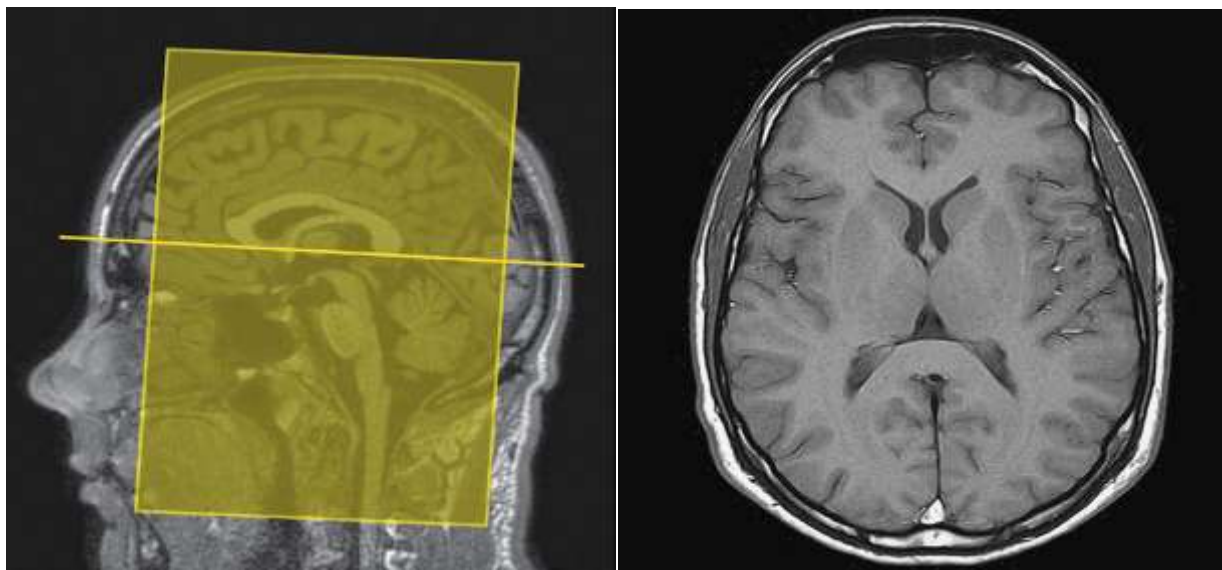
Axial IR T1-weighted image using a TI of 700ms with the level of the cuts demonstrated in sagittal T1 weighted images (left).
